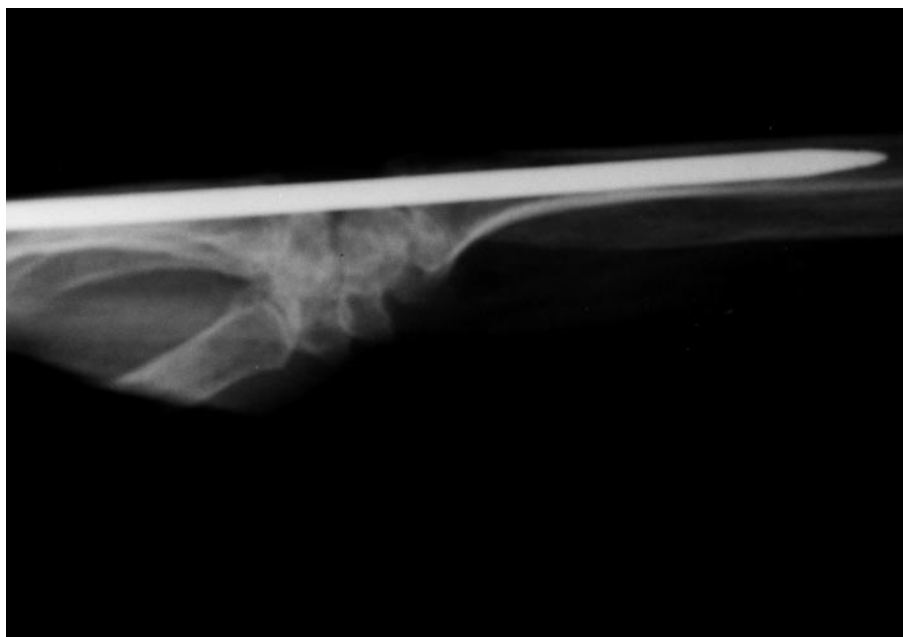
Lateral radiograph of pin crossing dorsum of the carpus.
